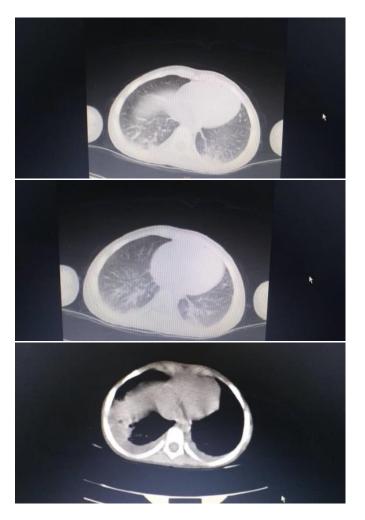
Chest computed tomography scan, ground glass
